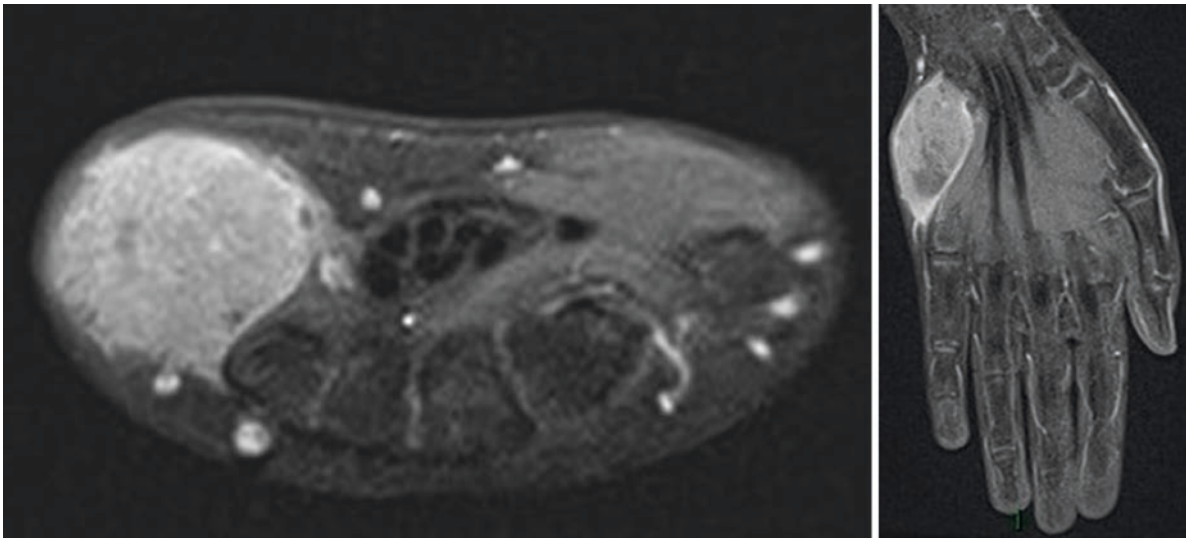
Girl, aged 15 years, with a left hand intramuscular mass on MRI corresponding to an alveolar rhabdomyosarcoma
